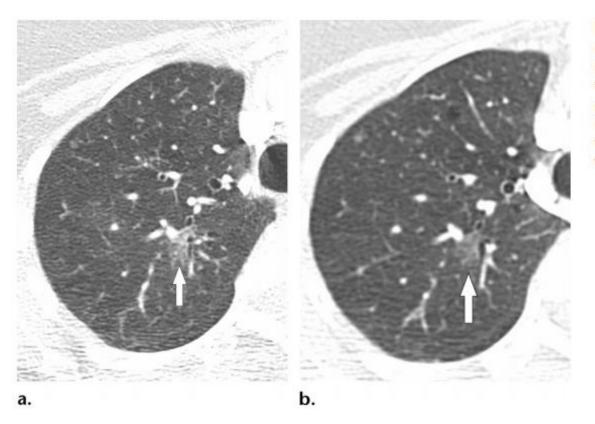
Invasive adenocarcinoma in a 66-year-old woman. (a) Axial contrast material–enhanced chest CT image (lung window settings) of the right upper lobe shows a ground-glass nodule (arrow). (b) Comparison axial CT image obtained 3 years earlier than a shows that the nodule had increased in attenuation centrally with time, without an overall change in size.
